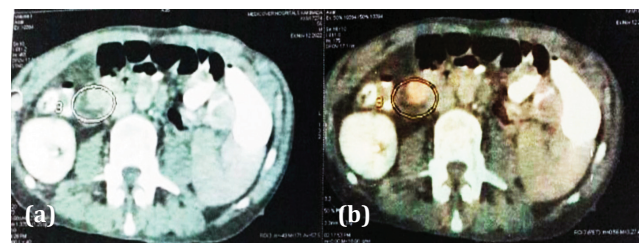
Case 6- 68Ga DOTATATE PET/CT before PRRT showing lesion in pancreas.
